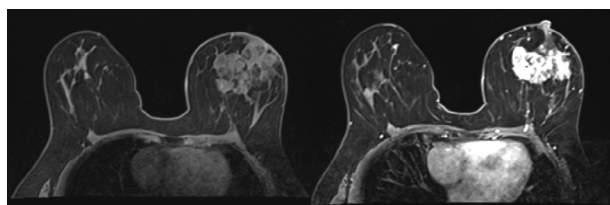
Breast MRI Axial Scan with T1 sequence: a solid, mass-type nodular formation at the supero-median-retroareolar site of the left breast: with early and intense contrast enhancement in post-contrast dynamic sequences; another smaller solid lesion of the right breast.
